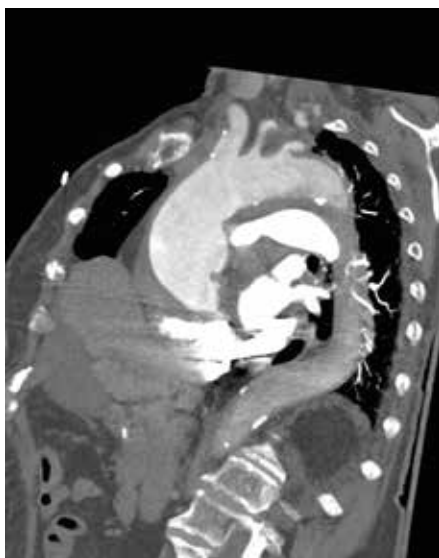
sagittal-oblique angio-CT of the thorax that shows the one-sided dilatation of the aortic aneurysmatic wall
